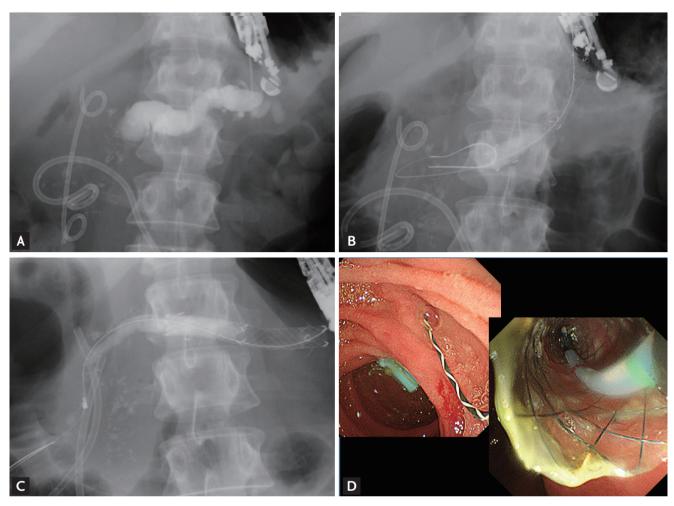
Representative case of endoscopic ultrasonography (EUS)-guided rendezvous cannulation and retrograde insertion of a fully covered self-expandable metal stent (FC-SEMS) for a stricture in the main pancreatic duct. (A) EUS-guided anterograde pancreatographic image showing dilation of the main pancreatic duct with a severe stricture at the head of the pancreas. (B) EUS-guided anterograde insertion of the FC-SEMS for internal drainage of pancreatic juice. (C) EUS-guided anterograde insertion of a guidewire into the duodenum through the dorsal pancreatic duct. (D) Endoscopic images showing retrograde insertion of a second FC-SEMS into the main pancreatic duct via the minor papilla.
